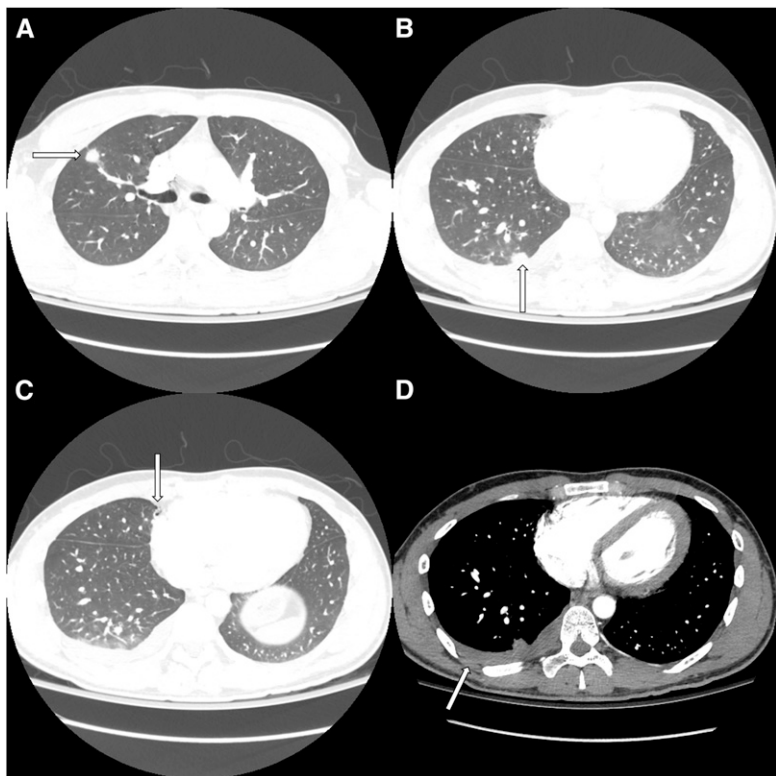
Multiple computed tomographic scan images of the chest, revealing (A–C) multiple pulmonary nodules (arrows), including (C) a cavitary nodule (arrow) as well as (D) a pleural effusion (arrow).
